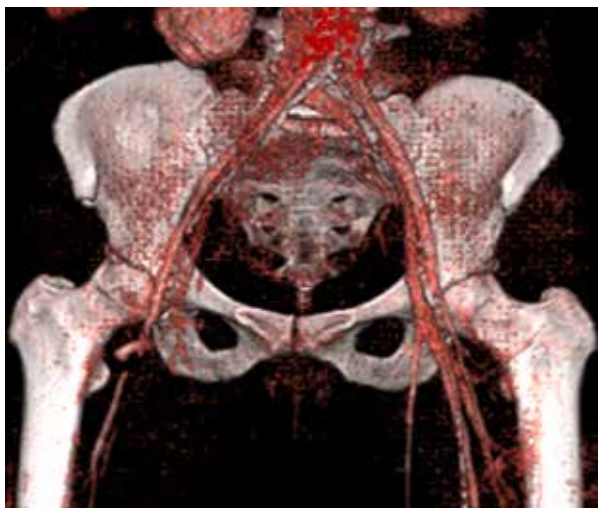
CT-angio, Extra ananatomical iliaco (prosthesis) popliteal lateral bypass, anastomoses are marked by yellow arrows.
